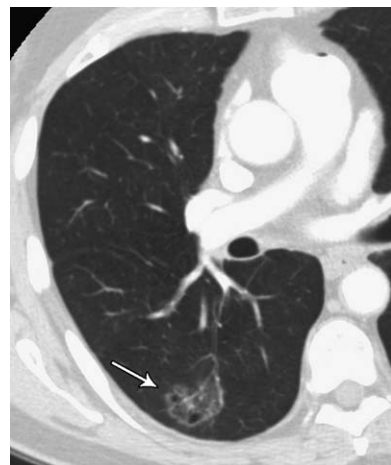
A 73-year-old man with history of bronchioloalveolar cell carcinoma of the left lung. CT scan shows multiple ground glass nodules, some of which show central lucencies or cysts (*arrow*).
